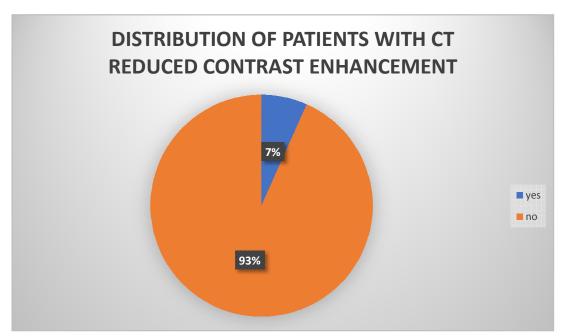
Distribution of patients with CT reduced contract enhancement
